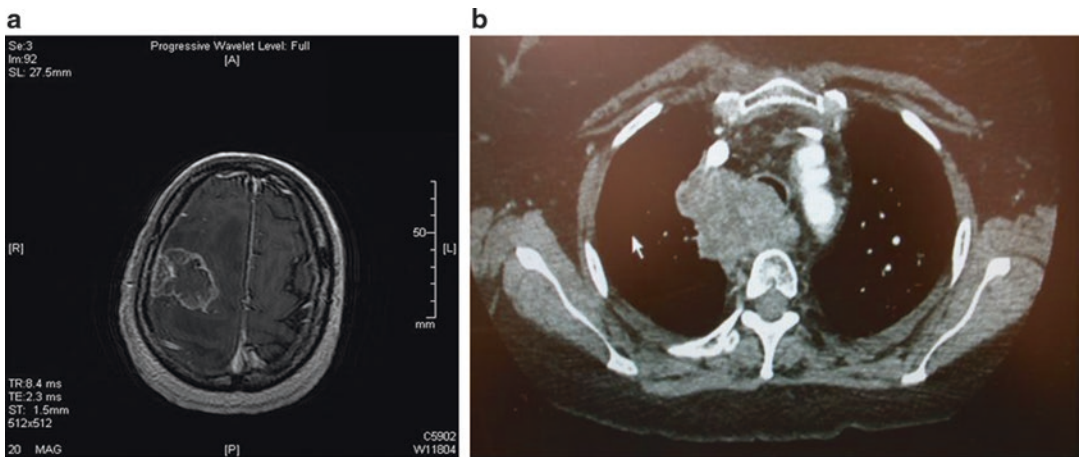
(a) An axial T1-weighted MRI with contrast of the brain showing a large right frontoparietal ring-enhancing brain mass. (b) A contrasted CT of the chest depicting a right-sided thoracic mass
